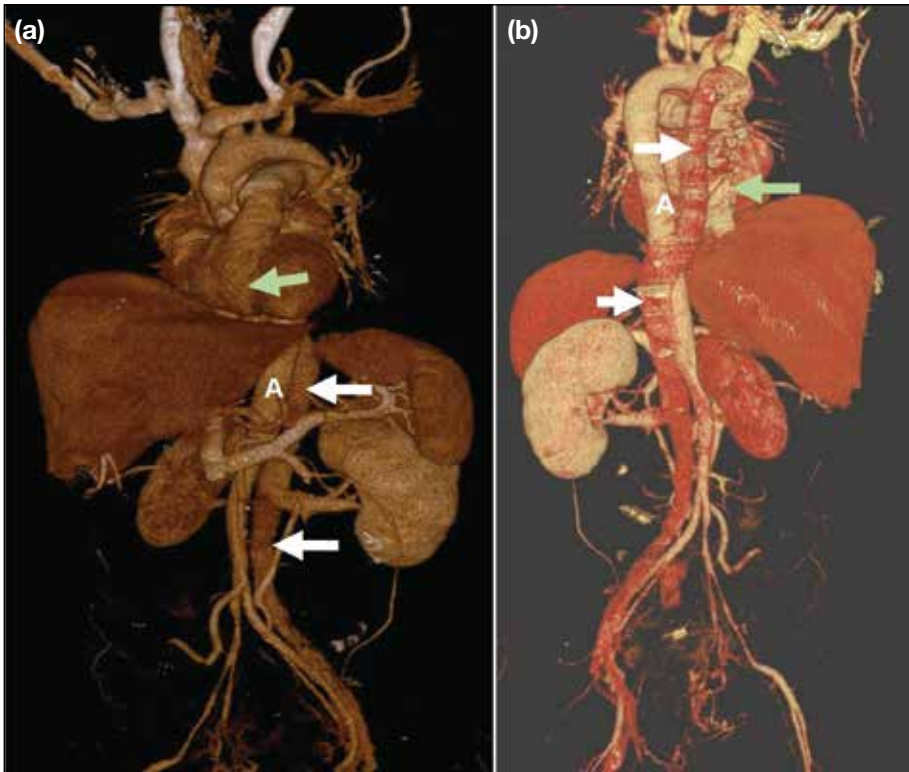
(a) Anterior and (b) posterior volume-rendered contrast-enhanced computed tomography images show a left inferior vena cava with hemiazygos continuation, crossing the midline posterior to the aorta (A) and draining into the azygos-superior vena cava pathway (white arrows). Hepatic veins are visible draining separately into the right atrium (green arrows).
